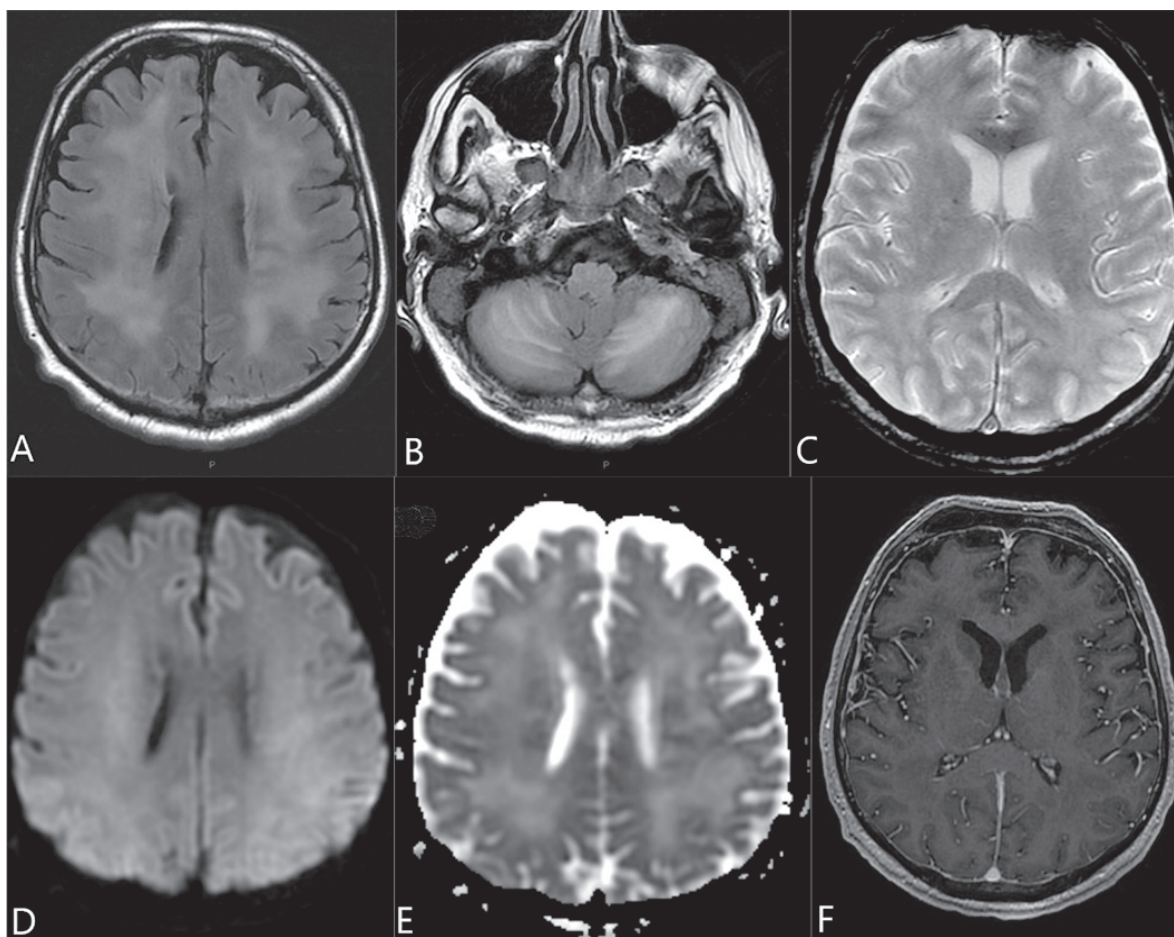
An axial MR imaging of the brain. (A,B) FLAIR and (F) post-contrast T1-weighted images showed non-enhanced diffuse, bilateral, symmetric, confluent hyperintensities located in the deep and subcortical white matter and cerebellum, suggesting vasogenic edema. (C) T2-star images showed microbleeds in corpus callosum, capsula interne of the right and basal ganglia on the right side. (D,E) Paired diffusion-weighted imaging and apparent diffusion coefficient showed non-diffusion restriction.
